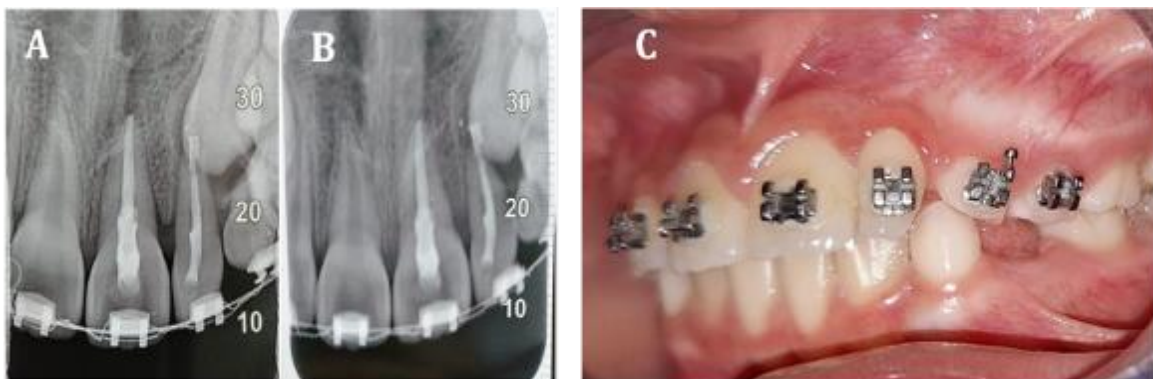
Follow up; Radiographic (A) After 1 month. (B) After 2 month. (C) Intraoral examination after 2 month
